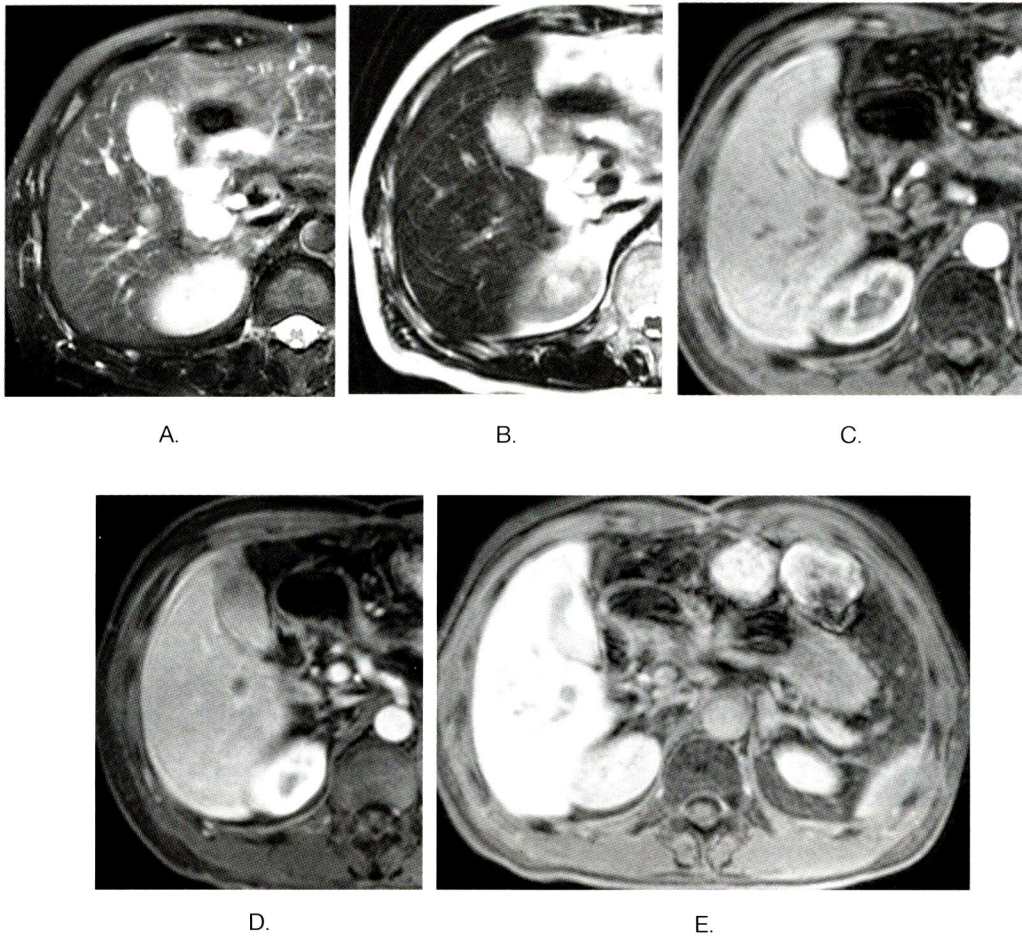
A-E MRI findings of Case 6
